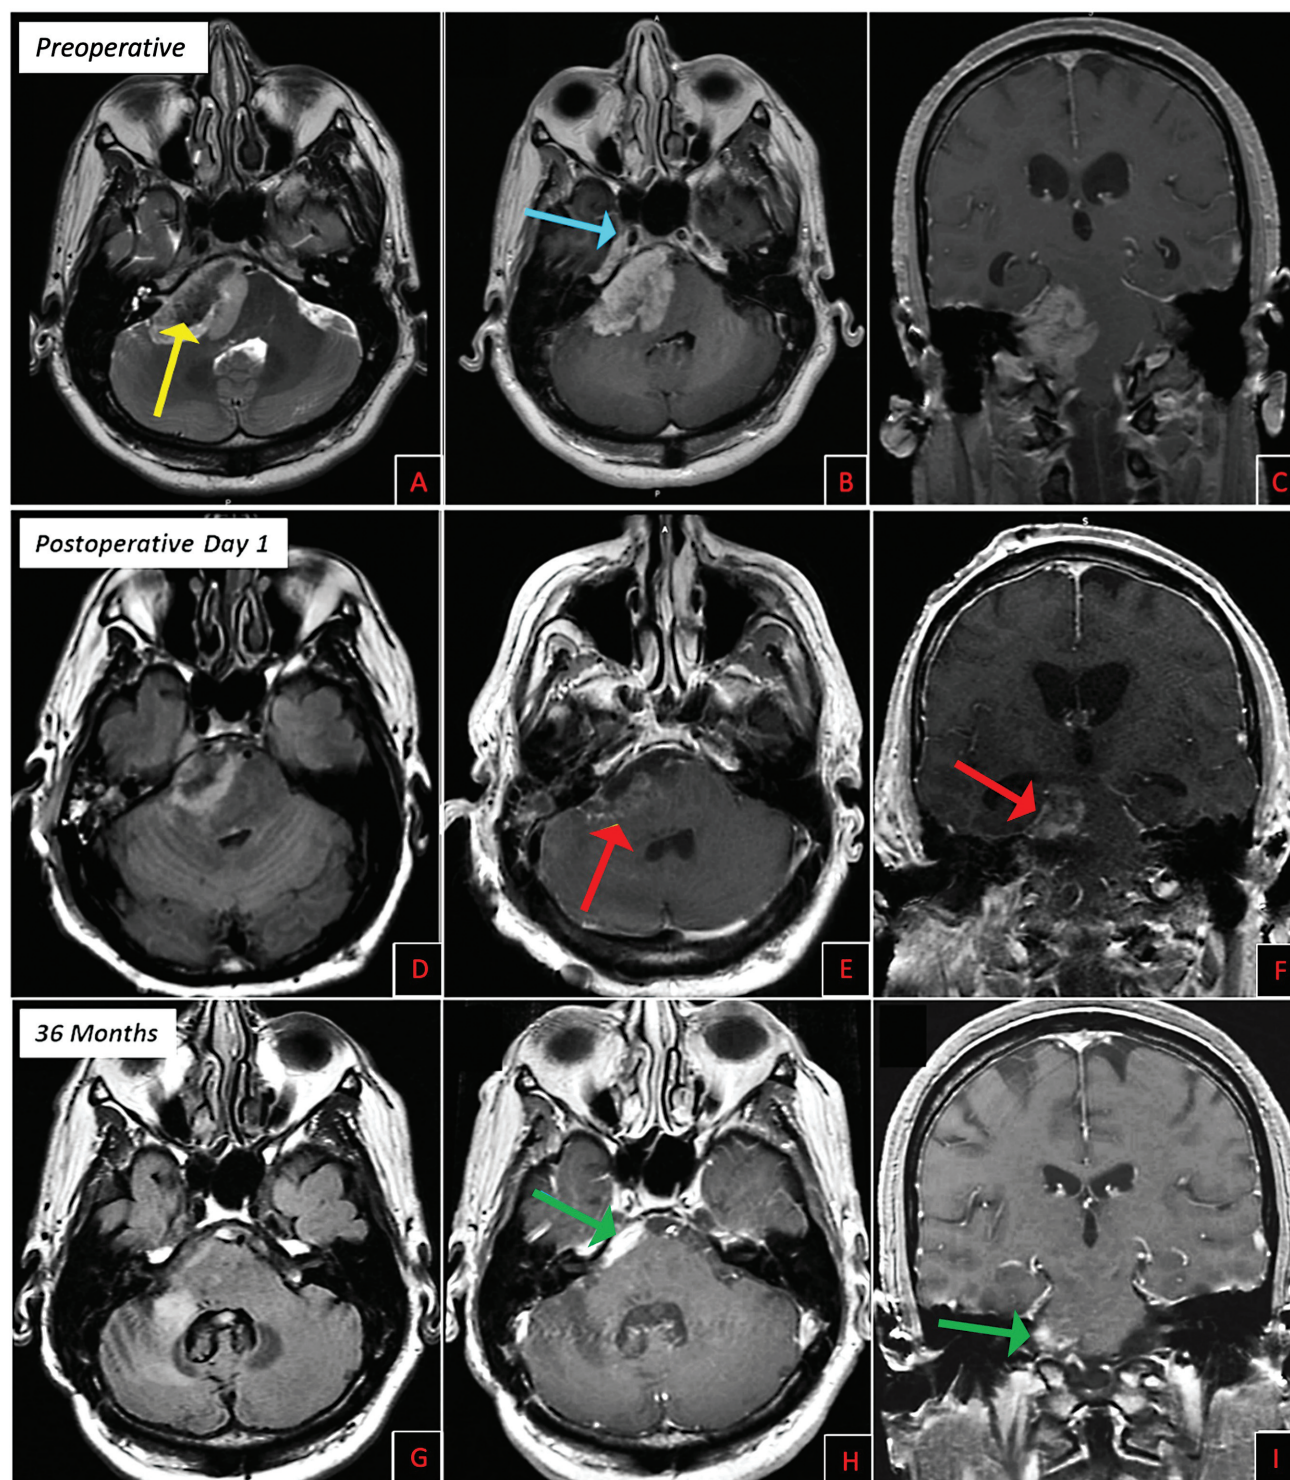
Neuroimaging of the representative case study. Preoperative magnetic resonance imaging (MRI) demonstrating a $5.2 \times 4.9 \times 2.9$ cm right cerebellopontine angle (CPA) tumor with pontine displacement and Meckel's cave extension (blue arrow). Notable characteristics include (A) central T2 hypointensity with a cystic periphery (yellow arrow) and (B,C) heterogenous contrast enhancement. Postoperative MRI 24 hours after subtotal tumor resection demonstrating (D) minimal brainstem and cerebellar edema with (E,F) nodular enhancement adjacent to the ventral pons and tentorium (red arrows). Postoperative MRI at 36 months revealing (G) stable cerebellar encephalomalacia and cystic change within the dorsal pons and (H,I) decreased enhancement in the right prepontine cistern and ventral pons (green arrows).
